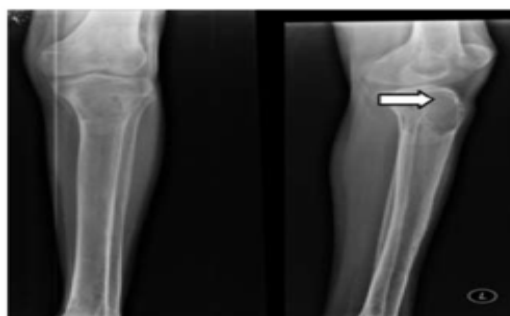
X-ray left knee joint view showing osteolytic lesion in left anterior /posterior and lateral view Frontal region (arrow) showing osteolytic lesion (arrow).
